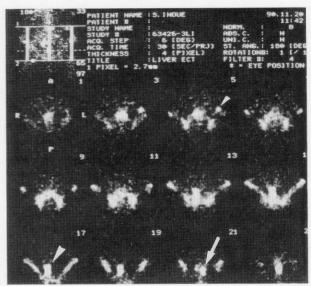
SPECT image of the pelvis. Normal pelvic bone marrow uptake and abnormal spotty uptakes in the left upper pelvis (small arrow head) and in the lower middle pelvis (large arrow head and arrow).
